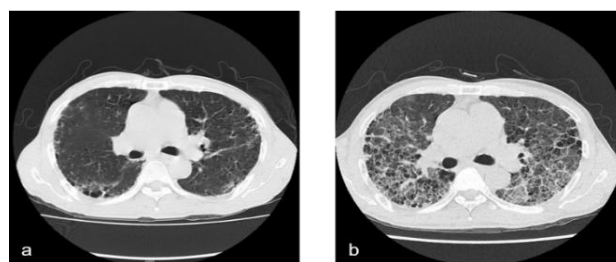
A male patient, aged 59, who presented with acute exacerbation of rheumatoid arthritis–interstitial lung disease for 2 months. (a) The HRCT was taken 2 months prior to ICU admission. (b) The HRCT after 2 months showed predominant reticular abnormalities and honeycombing.
